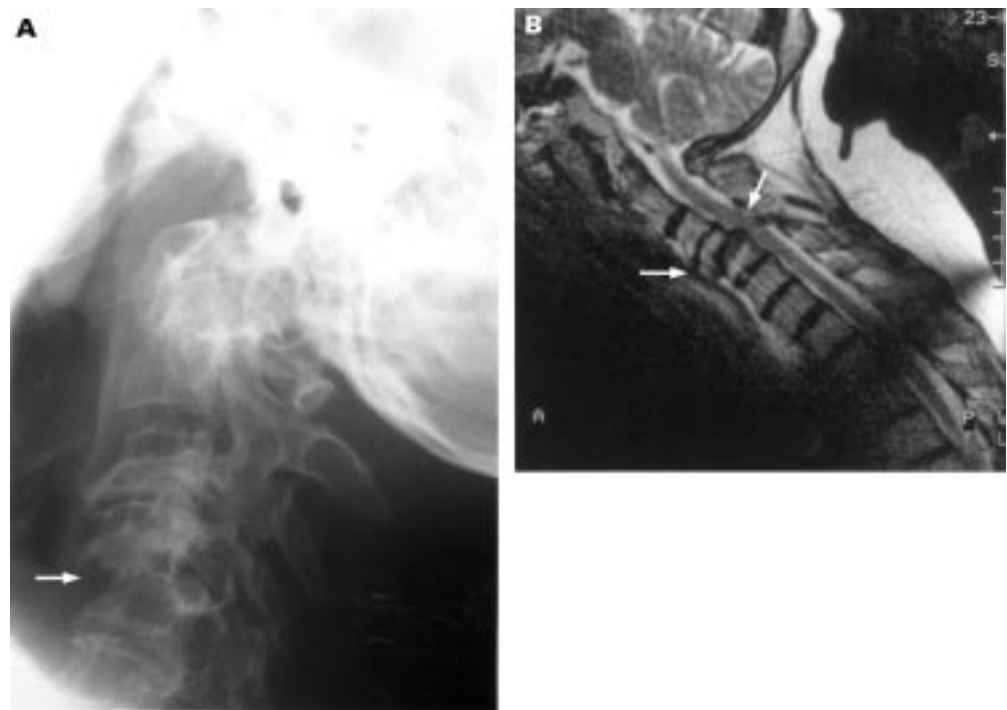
Lateral plain radiograph in flexion (A) and T2 weighted sagittal MR image (B) of the cervical spine showing C4–C5 subluxation of 9 mm with secondary spondylosis, discopathy, narrowing of the spinal subarachnoid space, and compression of the spinal cord.
